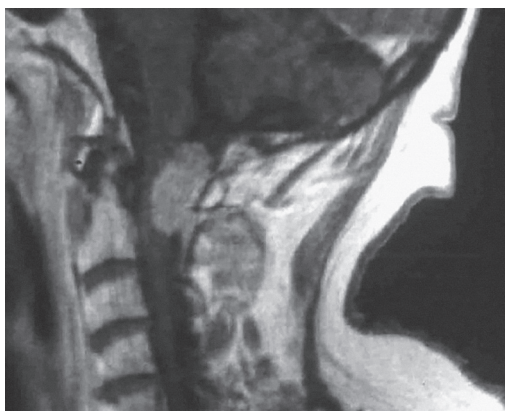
MRI showing a meningeoma at the C1–2 complex, compressing the spinal cord posteriorly.
